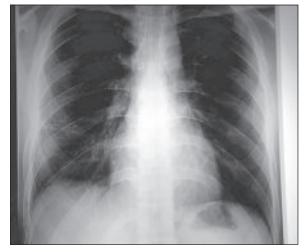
X-ray: Normal (After treatment) Source: Personal collection from my consultation chamber
